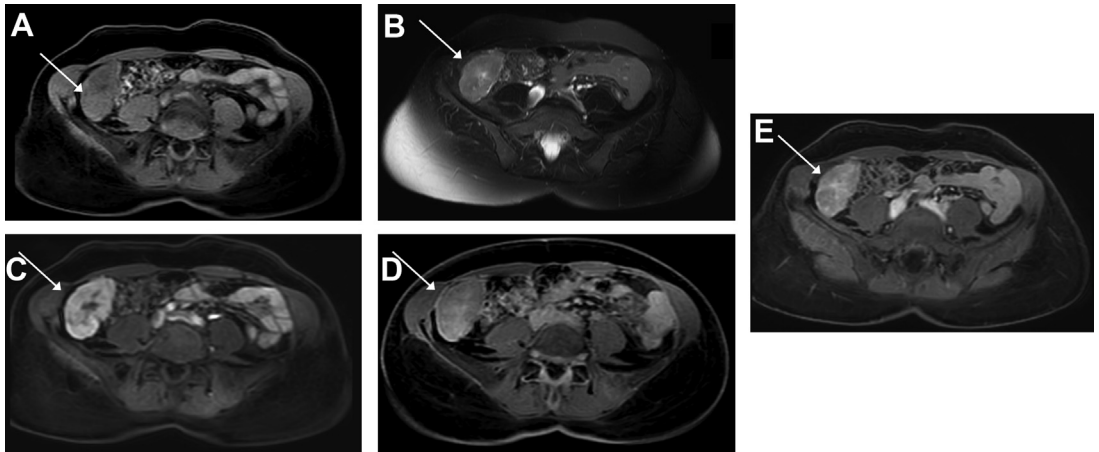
Pitfall of a lesion with central element. Pedunculated lesion, hypointense on T1-weighted fat-saturated image (A), slightly hyperintense on T2-weighted fat-saturated image (B), demonstrating arterial phase hyperenhancement after injection of gadobenate dimeglumine (0.1 mL/kg) (C) with washout in the delayed phase (D), apart from delayed hyperenhancement of a central element. In the hepatobiliary phase (E), the lesion was hypointense with only central accumulation of gadobenate dimeglumine. The final diagnosis determined by pathology was mixed hepatocholangiocarcinoma.
